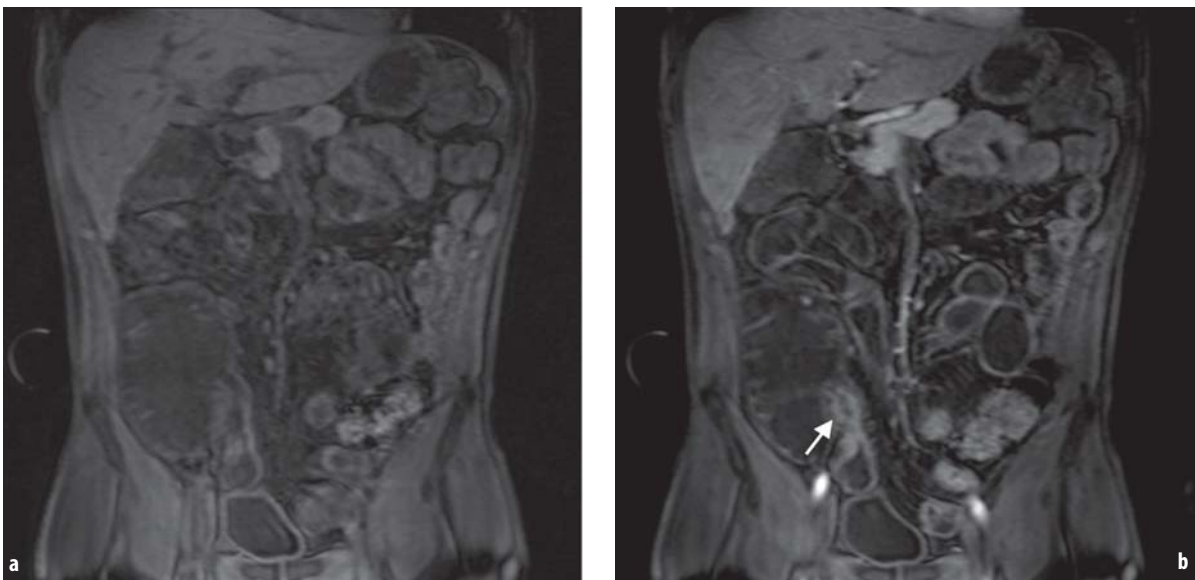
Coronal fat suppressed T1-weighted spoiled gradient echo sequence acquired before (a) and 30 s following intravenous administration of gadolinium chelate (b), demonstrating marked parietal enhancement of the distal ileal loop (arrow)
